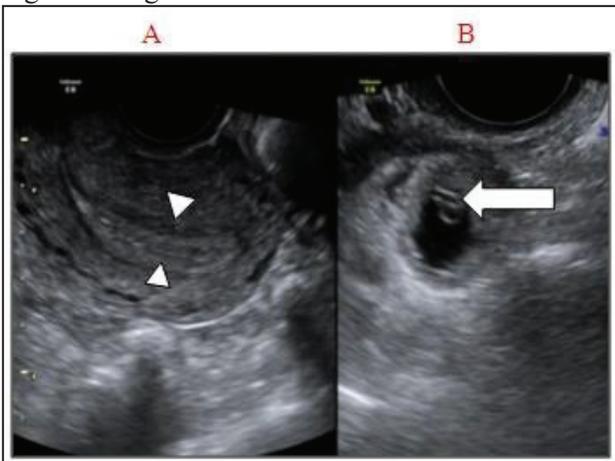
Sagittal transvaginal ultrasound image of the same patient showing thickened endometrium (between the arrowheads), however no intrauterine gestational sac was seen (A). Axial image of the right adnexa showed gestational sac with fetal pole (arrow), confirming the ectopic pregnancy (B).
